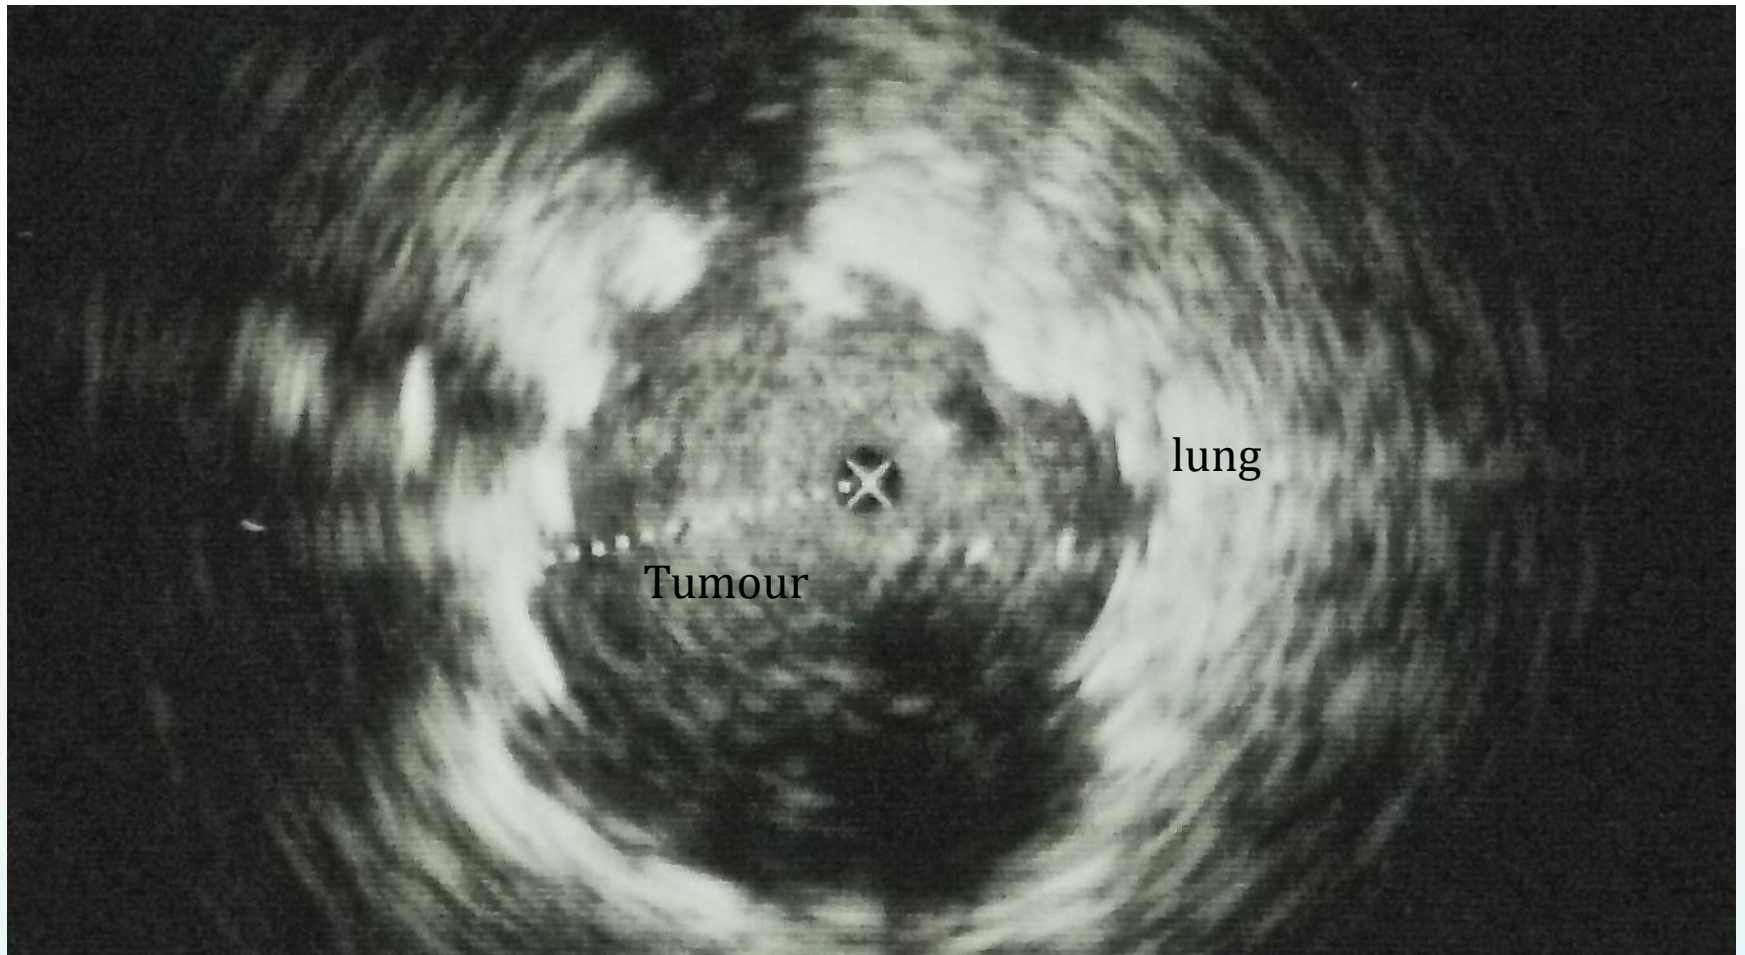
Ultrasound image of the left upper nodule in figure 1. Transbronchial biopsies performed through the guide sheath confirmed metastatic carcinoma from the breast. X denotes position of the miniature EBUS probe
